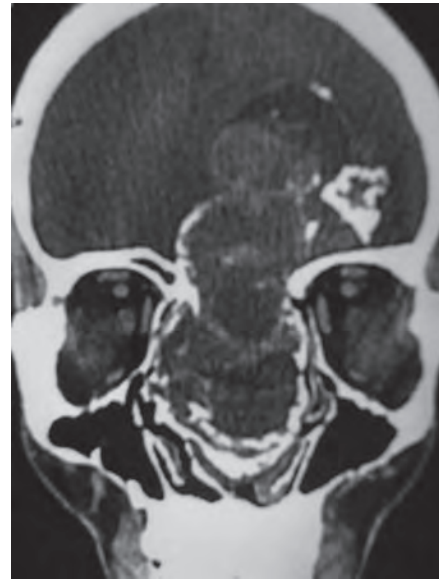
Esthesioneuroblastoma: Coronal contrast MR image showing the heterodense lesion filling up the nasopharynx, sphenoid sinus and reaching the sellar-suprasellar region with extension to the frontal lobes
